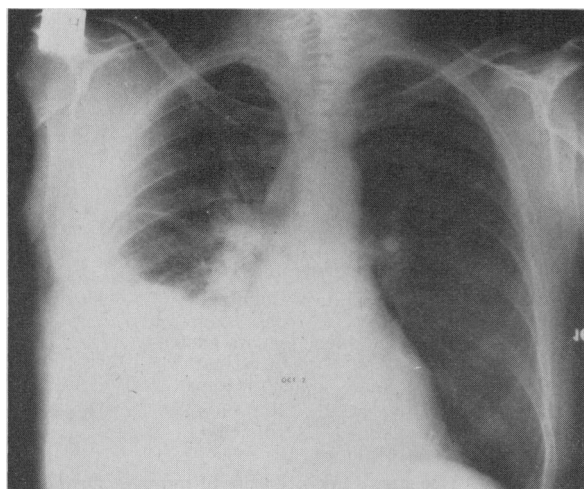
Radiograph taken on October 2 shows the reappearance of a right-sided pleural effusion.
